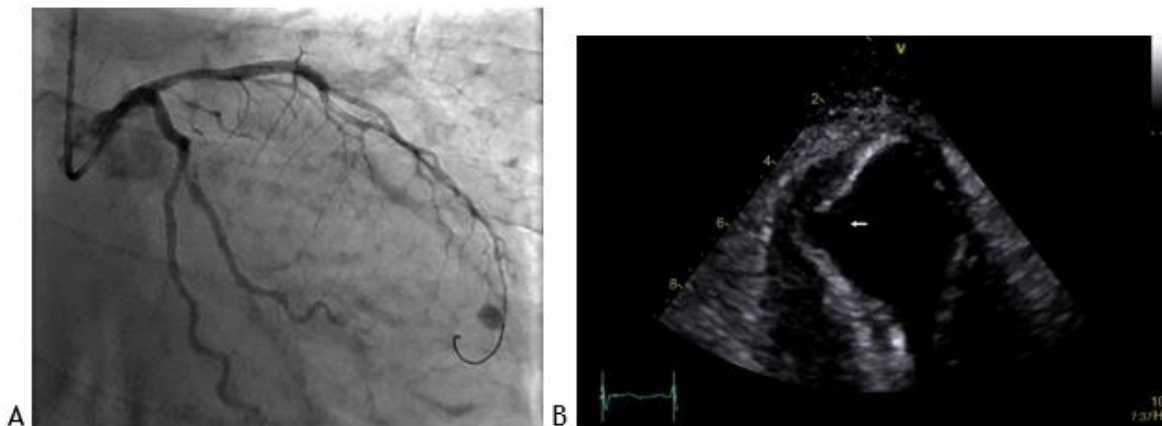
A) Coronary angiography after insertion of the intracoronary prosthesis (drug-eluting stents) and B) Transthoracic echocardiography performed one day after the beginning of the clinical history. 16 mm post-infarction interventricular defect with irregular edges.
